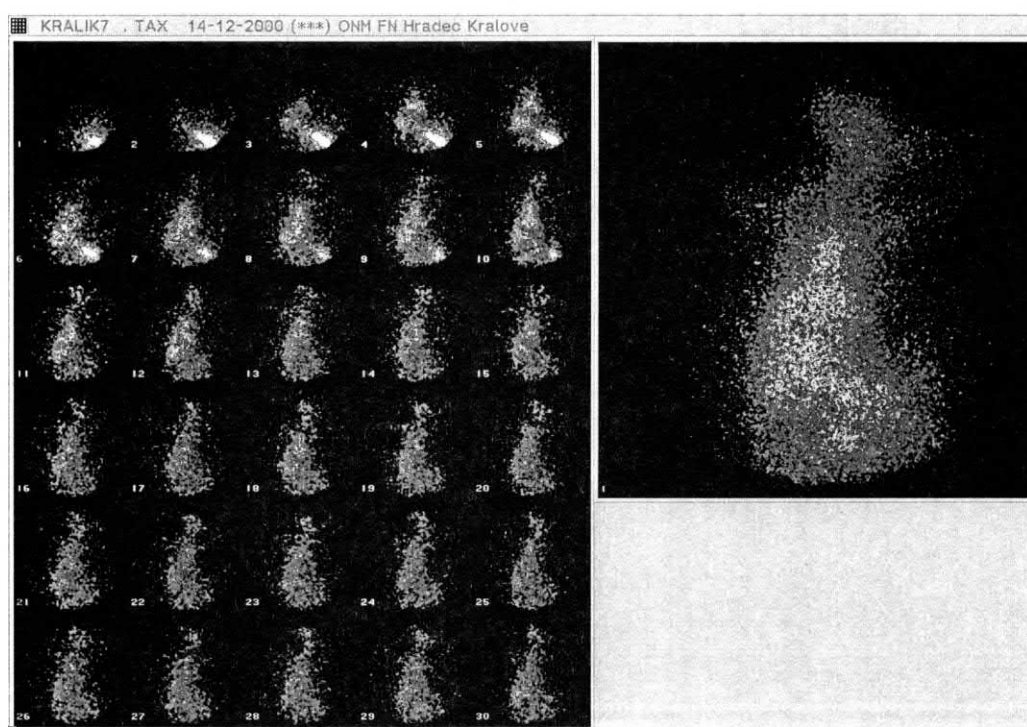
^{131}I -docetaxel administered into the portal vein (dynamic scintigraphy 0–5 min. pictures no. 1–30, static mode 5.–12. min - see right big picture)
